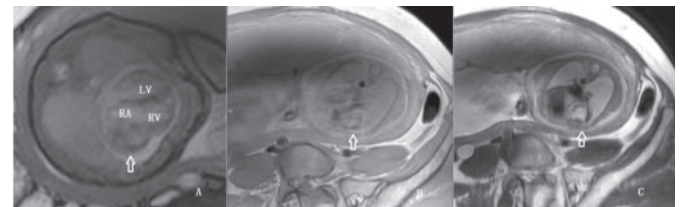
Fetal magnetic resonance imaging (MRI). (A): MRI shows a mass with a broad base of attachment arising from the wall of right atrium, that with apparent pericardial effusion; (B): Slightly hypointensity on T1WI; (C): Hyperintensity on T2WI. RV, right ventricle; RA, right atrium; LV, left ventricle.
